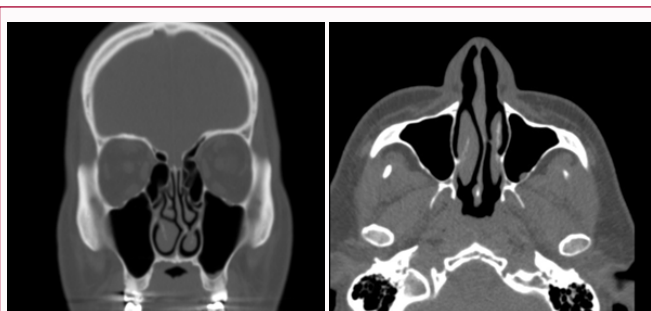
The post treatment CT scan.
